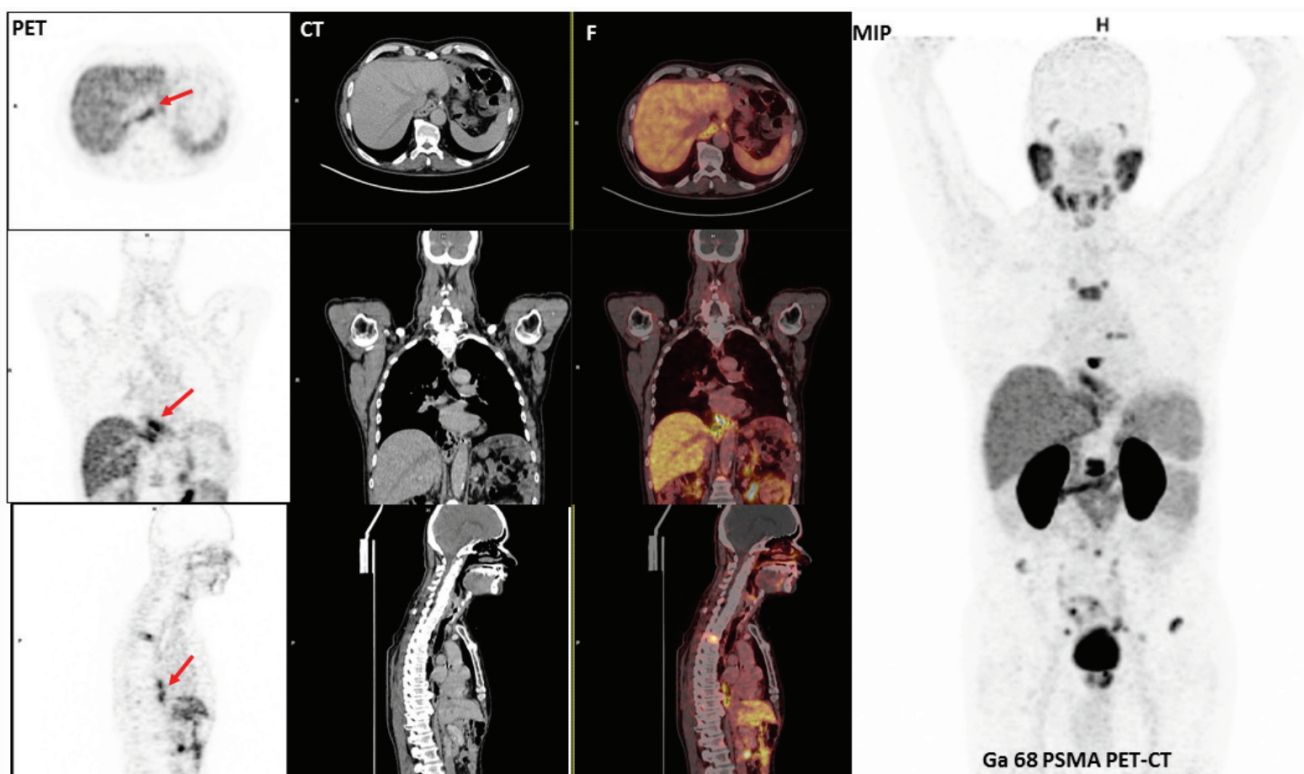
Gallium-68 (^{68}Ga) prostate-specific membrane antigen 11 (PSMA) positron emission tomography/computed tomography (PET/CT) shows increased uptake at multiple metastatic skeletal lesions in the vertebral column and pelvic bones as well as linear PSMA accumulation at the esophago-jejunosomy line (red arrows). PSMA is a type 2 transmembrane protein that acts as a glutamate carboxypeptidase enzyme (1,2). Owing to its high expression in prostate cancer cells, PSMA is often used conveniently as a target for diagnostic and therapeutic purposes in nuclear medicine. Normal ^{68}Ga PSMA uptake might be seen in the following structures, with descending avidity: Kidneys (8 times higher than hepatic uptake), submandibular glands, parotid glands (3 times higher than hepatic uptake), descending duodenum, lacrimal glands, spleen, descending colon, Waldeyer ring in the neck, vocal cords, liver, and rectum (3). In case of benign lesions, most ^{68}Ga PSMA uptake is of low intensity or non-focal, with some notable exceptions (e.g., cutaneous, vertebral, and hepatic hemangiomas) exhibiting prominent uptake (4). Prostate cancer commonly spreads to the bones and lymph nodes. Although the spread of prostate cancer to the gastrointestinal tract is very rare, the possibility of metastasizing to the stomach should be kept in mind when a patient presents with gastrointestinal symptoms or hemorrhage (5). A few reports have demonstrated prostate carcinoma metastases in the stomach (5,6,7,8). A study by Shetty et al. (9) reported mild PSMA uptake in the gastric cardia in a case of high-grade invasive gastric adenocarcinoma. In another study, they found PSMA to be expressed by endothelial cells in keloids, granulation tissue from heart valves and pleura, and different phases of the cycling endometrium. It was reported that PSMA was not expressed by endothelium associated with Barrett's mucosa, even in the presence of associated dysplasia (10). It should be kept in mind that patients should be evaluated individually as PSMA uptake might be seen in both benign and malignant lesions.
